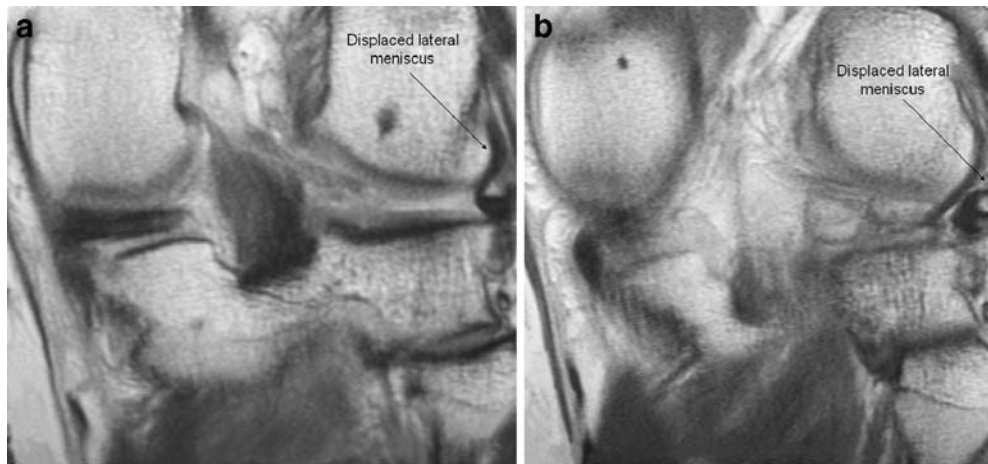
a Coronal MRI of the left knee. b Coronal MRI of the left knee, posterior to the prior image (a)
